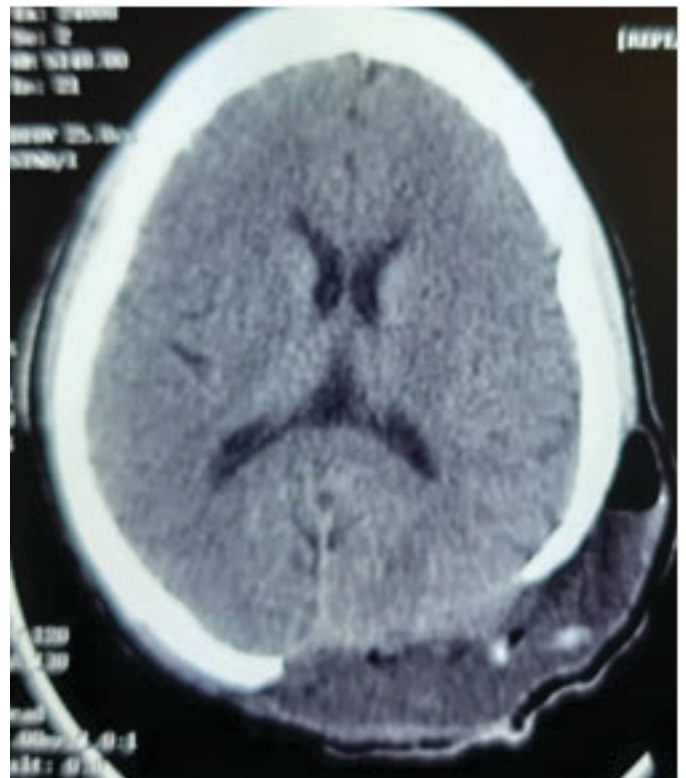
Immediate postoperative cranial CT.
